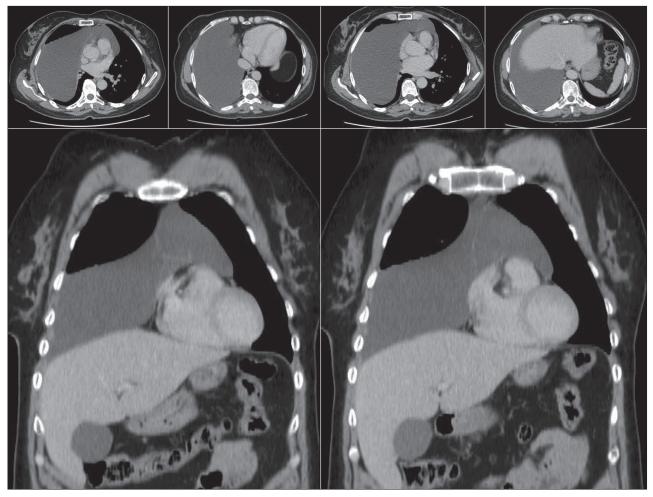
Preoperative CT scans of thorax
